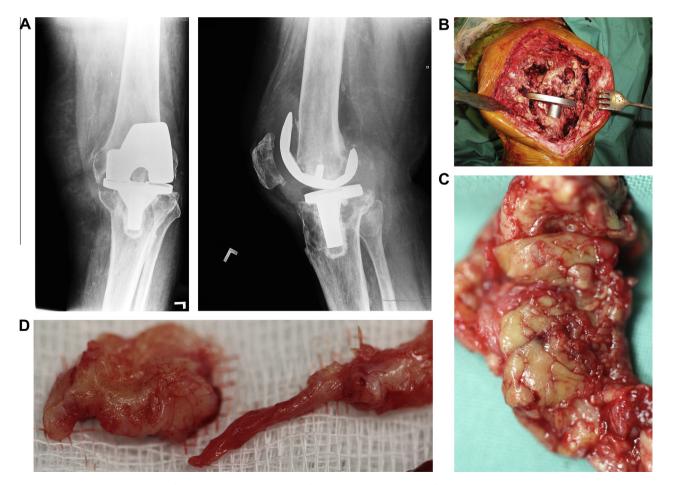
(a) Anteroposterior and lateral X-ray of extensive osteolysis around the femoral and tibial component of TKA 11 years postoperatively; (b) intraoperative view on the size of bone defects after removal of the failed femoral component and debridement of the osteolytic cavity; (c) from the surgeon's viewpoint, the interface tissue membrane surrounding a failed TKA appears to be similar to the same tissues from (d) aseptically failed total hip arthroplasty.
